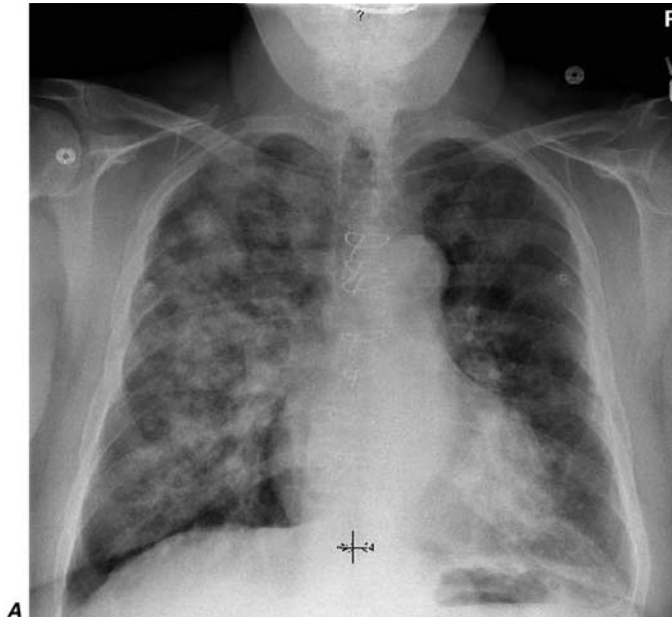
FIGURE e28-3 Bilateral ground-glass infiltrates due to alveolar hemorrhage from pulmonary capillaritis as seen in the same patient by (A) chest radiograph and (B) computed tomography.
